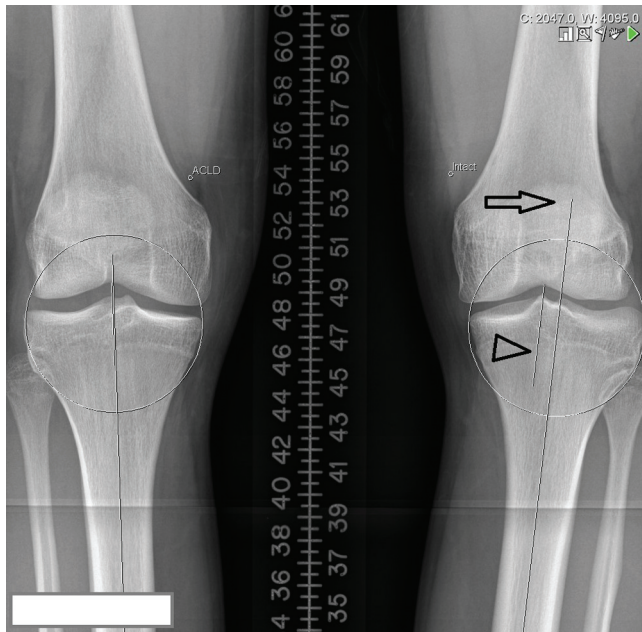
Anteroposterior weightbearing radiograph. The anterior cruciate ligament–deficient knee (left) has medial translation of the tibiofemoral mechanical axis when compared with the intact knee (right). The arrow points to the line that identifies the long axis of the tibia. The arrowhead points to a line parallel to the long axis of the tibia that passes through the most proximal aspect of the femoral intercondylar notch.
